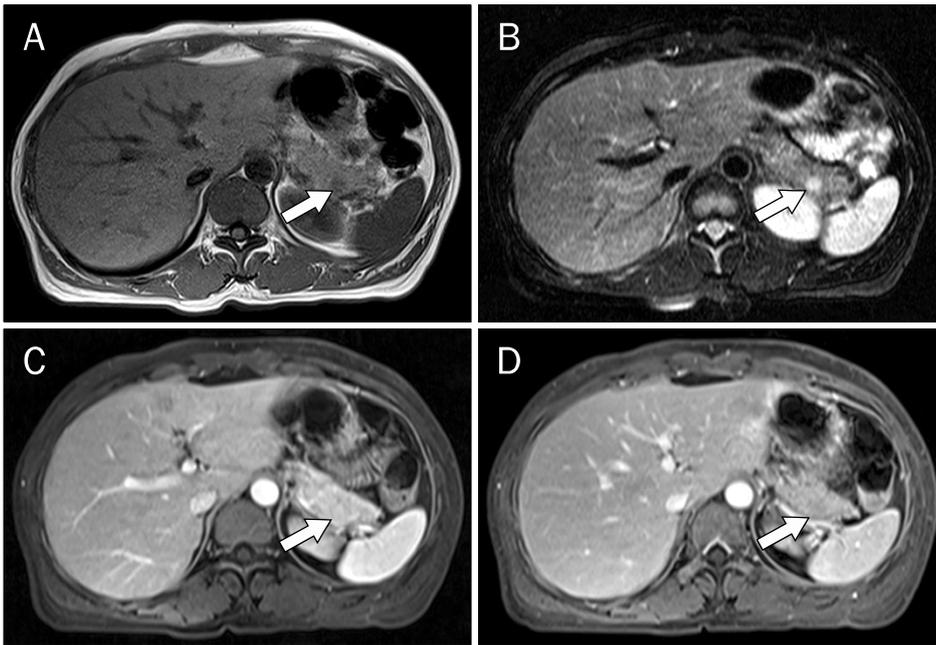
Magnetic resonance imaging of the patient. A 1 cm-sized pancreatic mass was detected in the tail of the pancreas. (A) The signal intensity of the mass was lower than that of the pancreatic parenchyma in the T1-weighted image (arrow). (B) The mass had higher signal intensity than the pancreas in the T2-weighted image (arrow). (C, D) With Gadolinium enhancement, the mass was enhanced in the arterial phase and became isointense in the delayed phase. It exhibited different signal intensity from the spleen (arrows).
